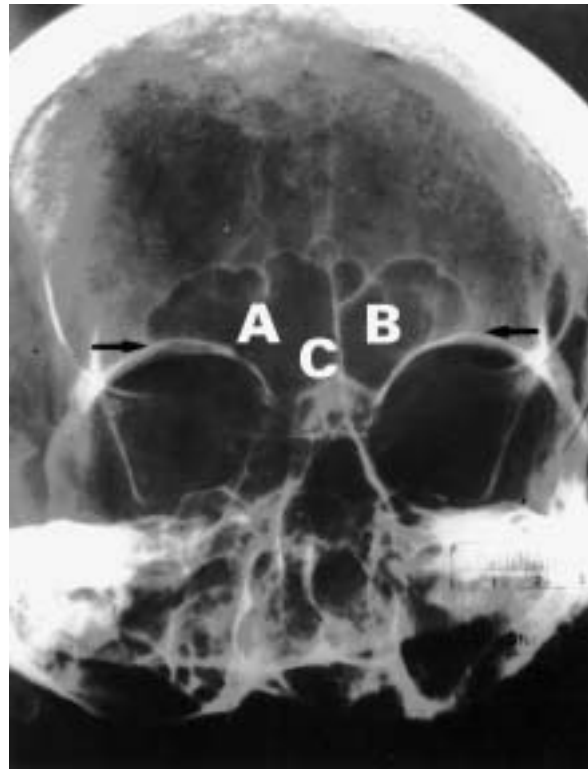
Radiograph of skull (PA view) showing: A, B — right and left frontal sinuses respectively; C — metopic suture; supraorbital margins are shown with arrows.
